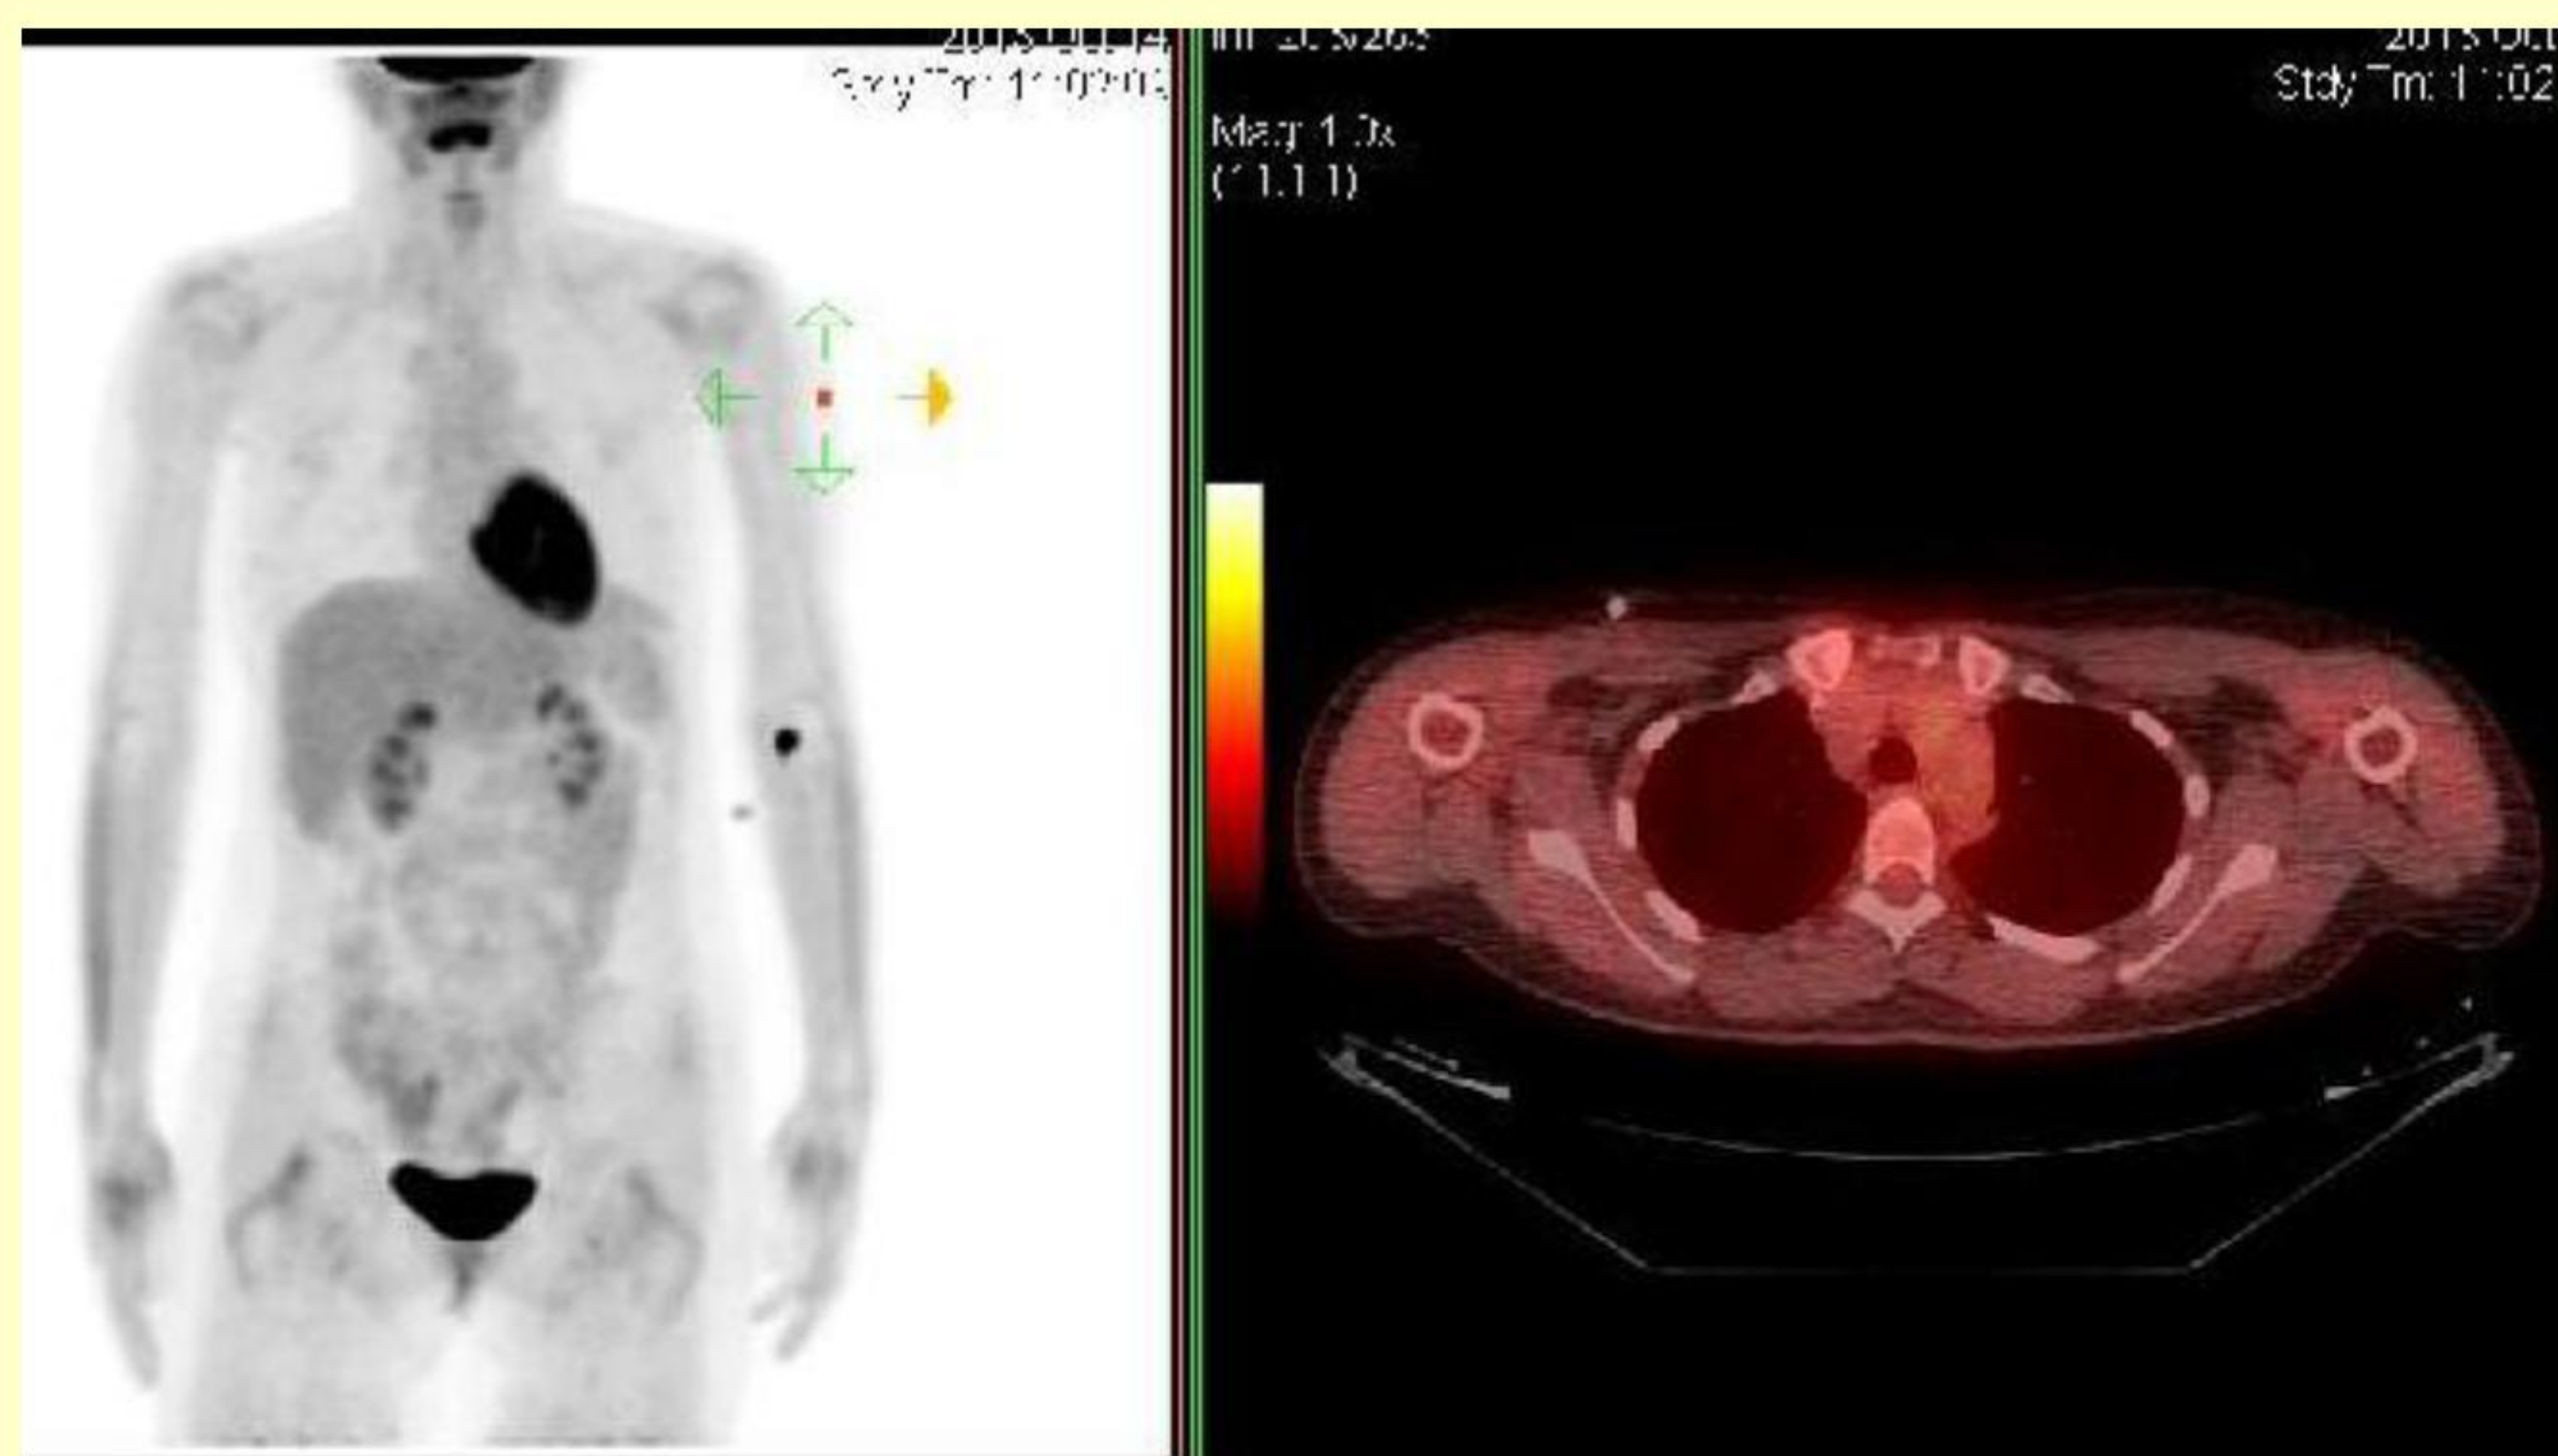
PET/CT scan after chemotherapy treatment. Complete remission achieved.
